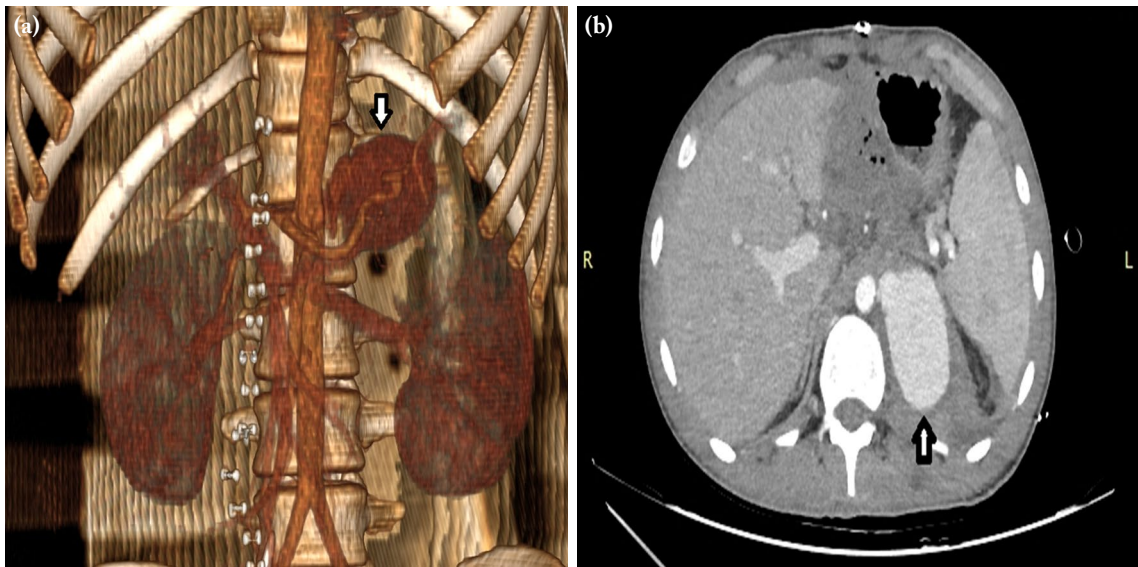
(a, b) Preoperative CTA images of traumatic abdominal aortic pseudoaneurysm at the level of CT. The tip of the white arrow shows aortic pseudoaneurysm.
